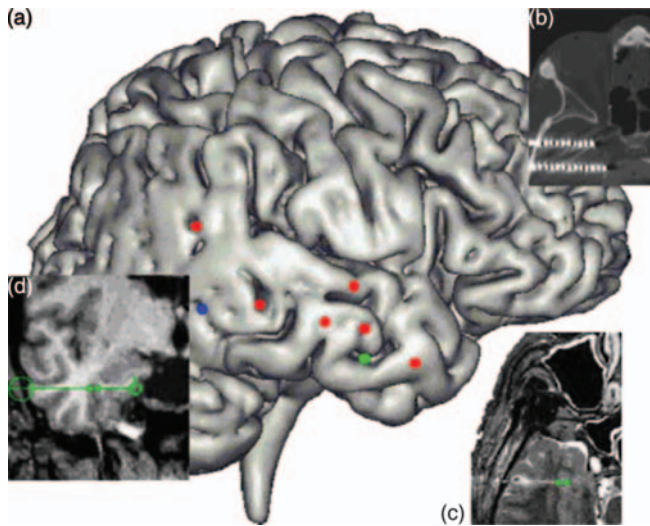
The stimulation of perirhinal cortex in object memory. (a) Image reconstruction of the patient's brain with the site of implantation of each electrode. The green line shows the implantation site of the electrode running through the perirhinal region. Red and blue dots indicate other electrode implantation points in the same brain. (b) A CT scan showing contact location of the electrodes (white dotted lines). (c) Axial MRI structural scan showing the thin trace left by the electrode (white line). (d) Coronal MRI scan showing the stimulation site (green dots) in the depth of the occipitotemporal sulcus of the right temporal lobe, an area that corresponds to the perirhinal region (see text for discussion). *Source: Barbeau et al., 2005.*
